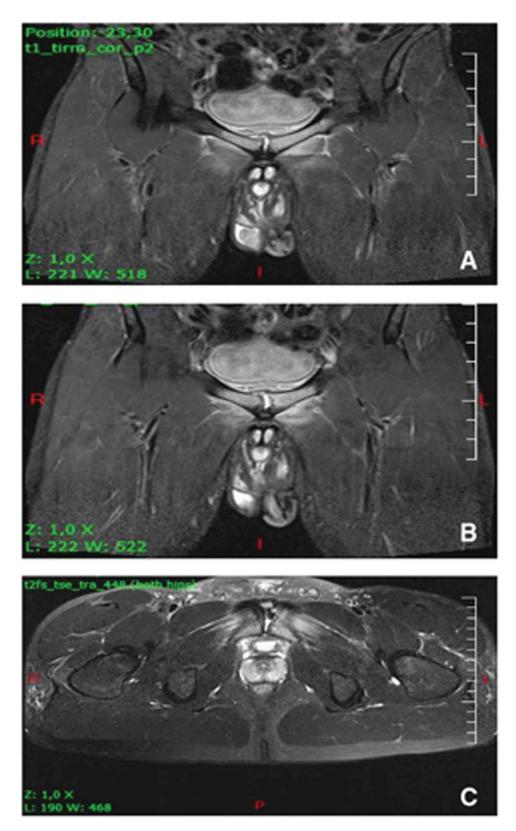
MRI of the pelvis ((A,B) longitudinal section, (C) transverse section) showing a small fluid collection around the pubic symphysis and extensive periarticular bone marrow oedema consistent with septic arthritis and a retropubic abscess.
